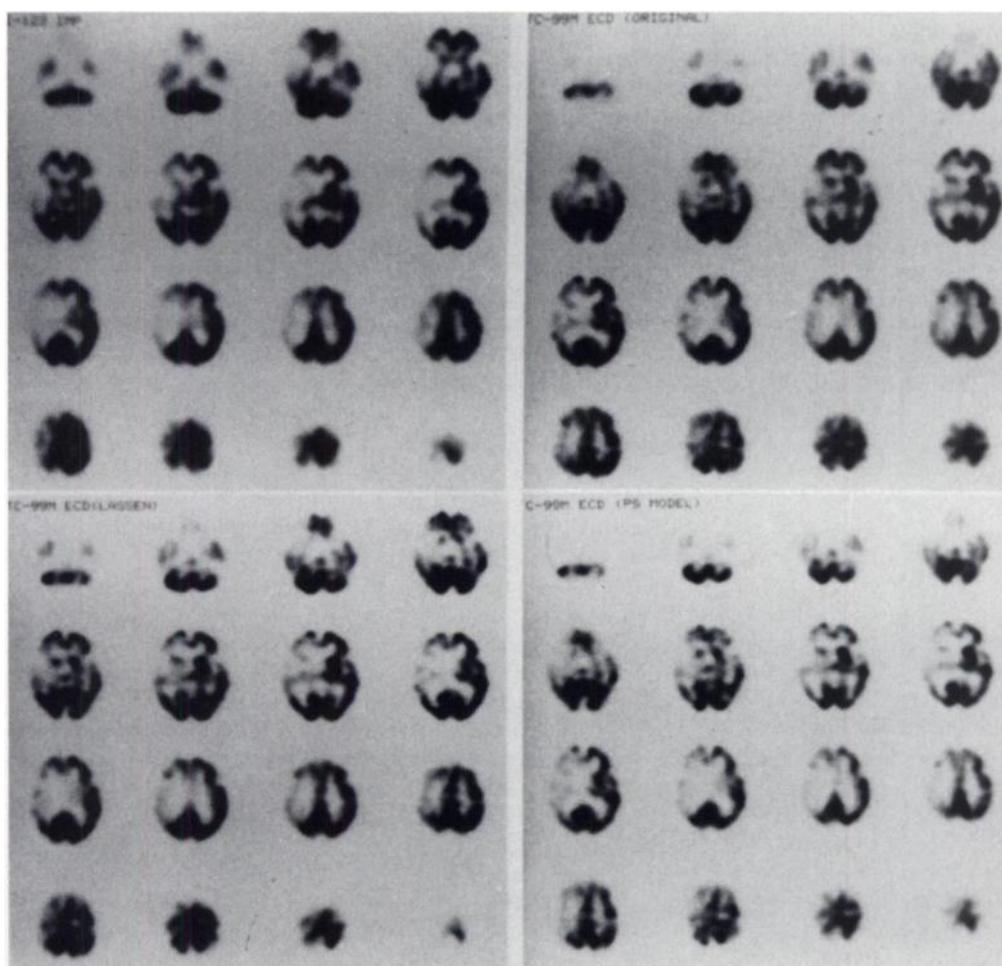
An 82-yr-old woman with left hemiparesis diagnosed as having minor stroke. A right common carotid angiogram reveals an occlusion of the right MCA. A T2-weighted MR image shows right putamen infarcts without cortical infarction. Acetazolamide challenge of ^{123}I -IMP SPECT image demonstrated a reduction in vasodilatory capacity of the right MCA territory (left top). Acetazolamide challenge of ^{99m}Tc -ECD SPECT image demonstrated a reduction vasodilatory capacity of the right MCA territory (right top). Underestimation of reduced vasodilatory capacity in the right MCA area is noted when compared with the ^{123}I -IMP SPECT image. This poor contrast is modified in SPECT images with linearization corrections. The contrast of corrected SPECT images by the PS model (right bottom) is better than that of Lassen's linearization correction (left bottom).
